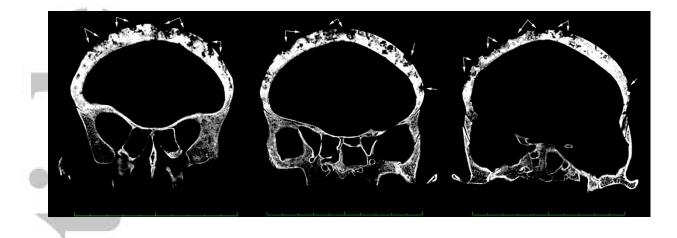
Coronal CT sections of cranium CG19O-1808, note the extensive bone destruction of the external table and to a lesser extent, the diploë (arrows)
